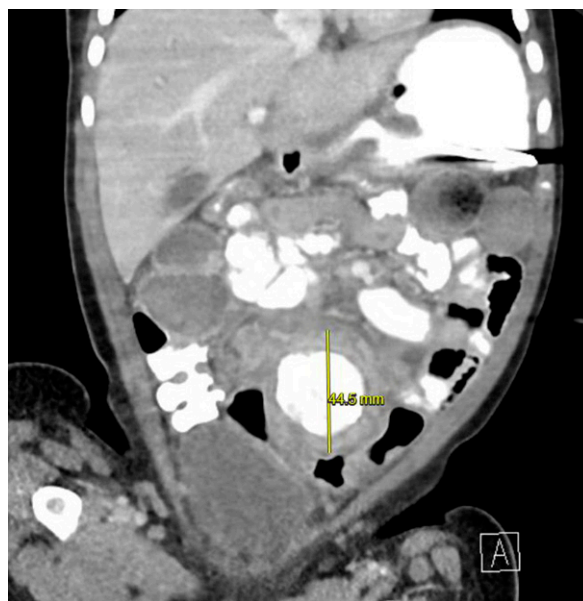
Computed tomographic scan of the abdomen/pelvis with contrast.
